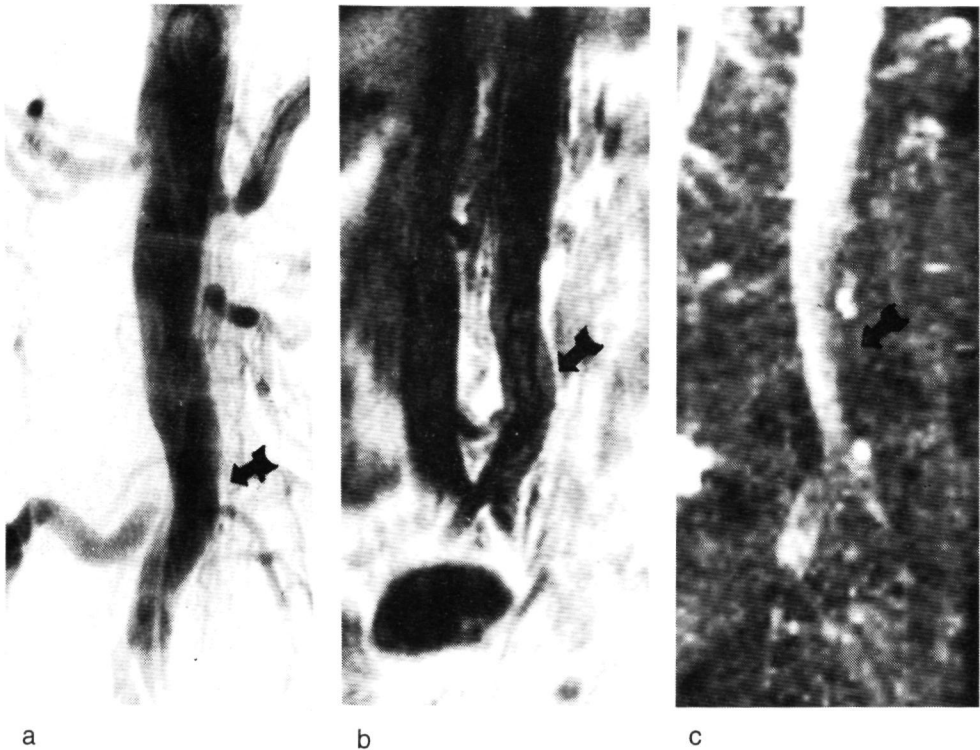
A 45 year old female patient who was known with cerebral vascular disease and intermittent claudication which first revealed several months before the intraarterial digital subtraction angiography (iaDSA; Figure 12.2a) and magnetic resonance imaging (MRI; Figure 12.2b) and magnetic resonance angiography (MRA; Figure 12.2c) were performed. She was known with 20 pack years of smoking and normal blood pressure measurements (130 mmHg and 85 mmHg, systolic and diastolic, respectively). The blood levels of protein C, antithrombin 3, glucose, cholesterol, triglycerides, creatinine, and liver enzymes (aspartate amino-transaminase and alanine amino-transaminase) were within normal ranges. Her post-load plasma homocysteine level was  $127 \mu\text{mol/L}$  (normal control value is below  $52 \mu\text{mol/L}$ ). IaDSA (Figure 12.2a) and gT1 MRI (Figure 12.2b) revealed 30% stenosis at both sides of the abdominal aorta, 60% stenosis at the aortic bifurcation and the right common iliac artery, and 70% and 60% stenosis, respectively, at the left common iliac arterial segment.
